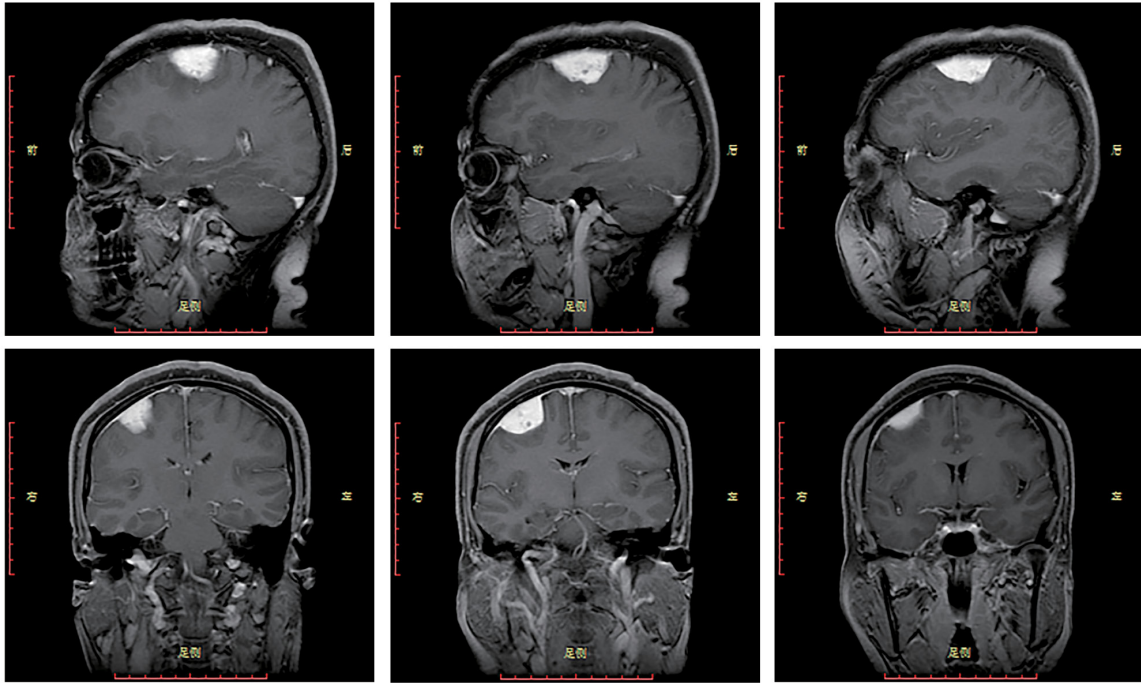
Magnetic resonance imaging showing a soft tissue mass attached to the meninges in the right frontal lobe.
